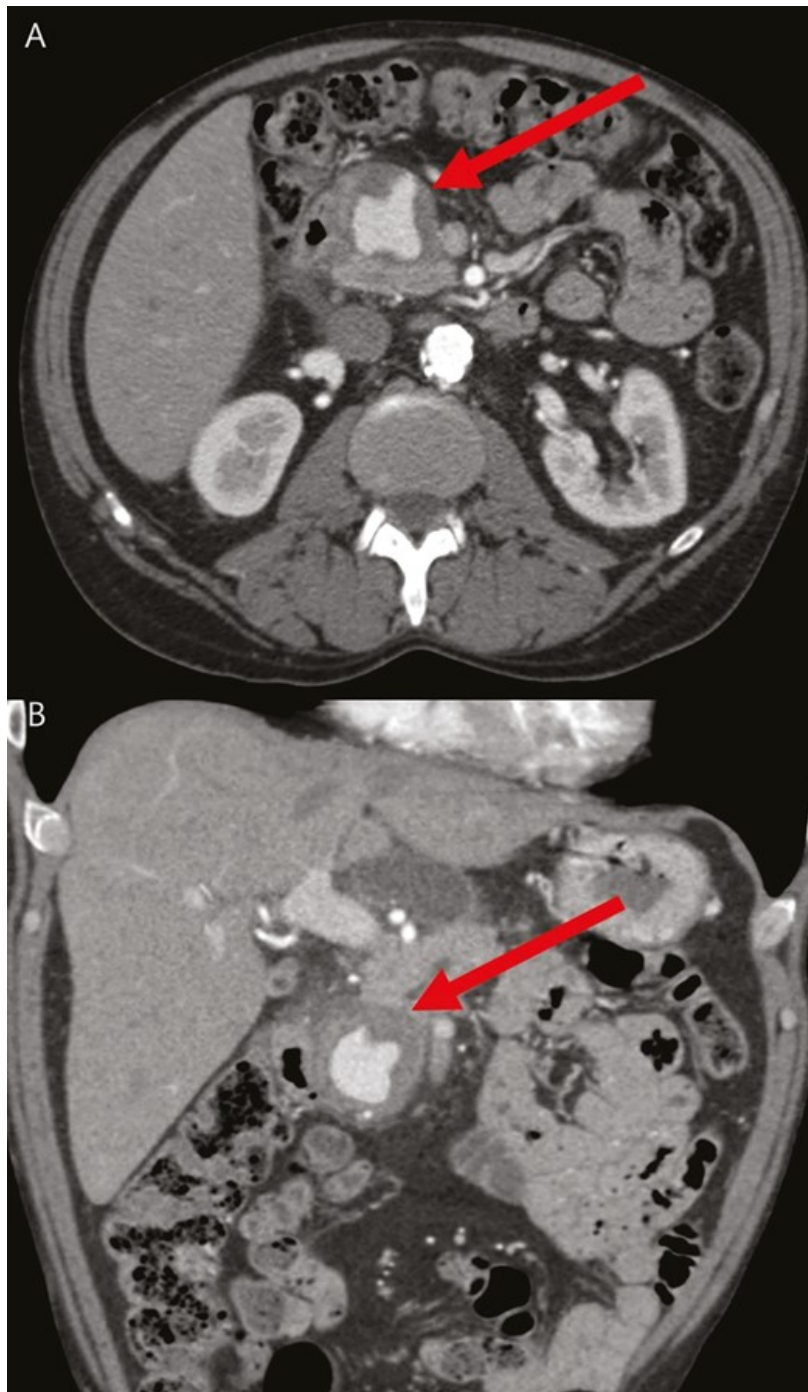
Representative axial (A) and coronal (B) computed tomography images demonstrating visceral artery pseudoaneurysm in necrotizing pancreatitis arising from a branch of the anterior pancreaticoduodenal artery (arrows).
